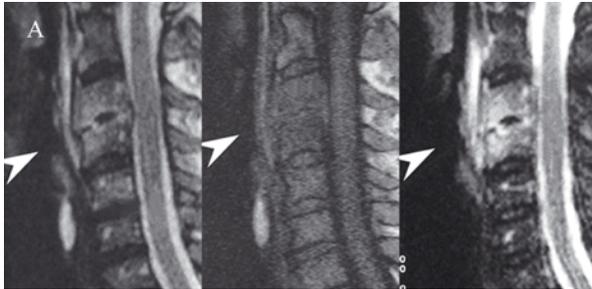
Case 1: A sagittal T1, T2-weighted and TIRM magnetic resonance images in the 9th month of the antituberculous treatment.
